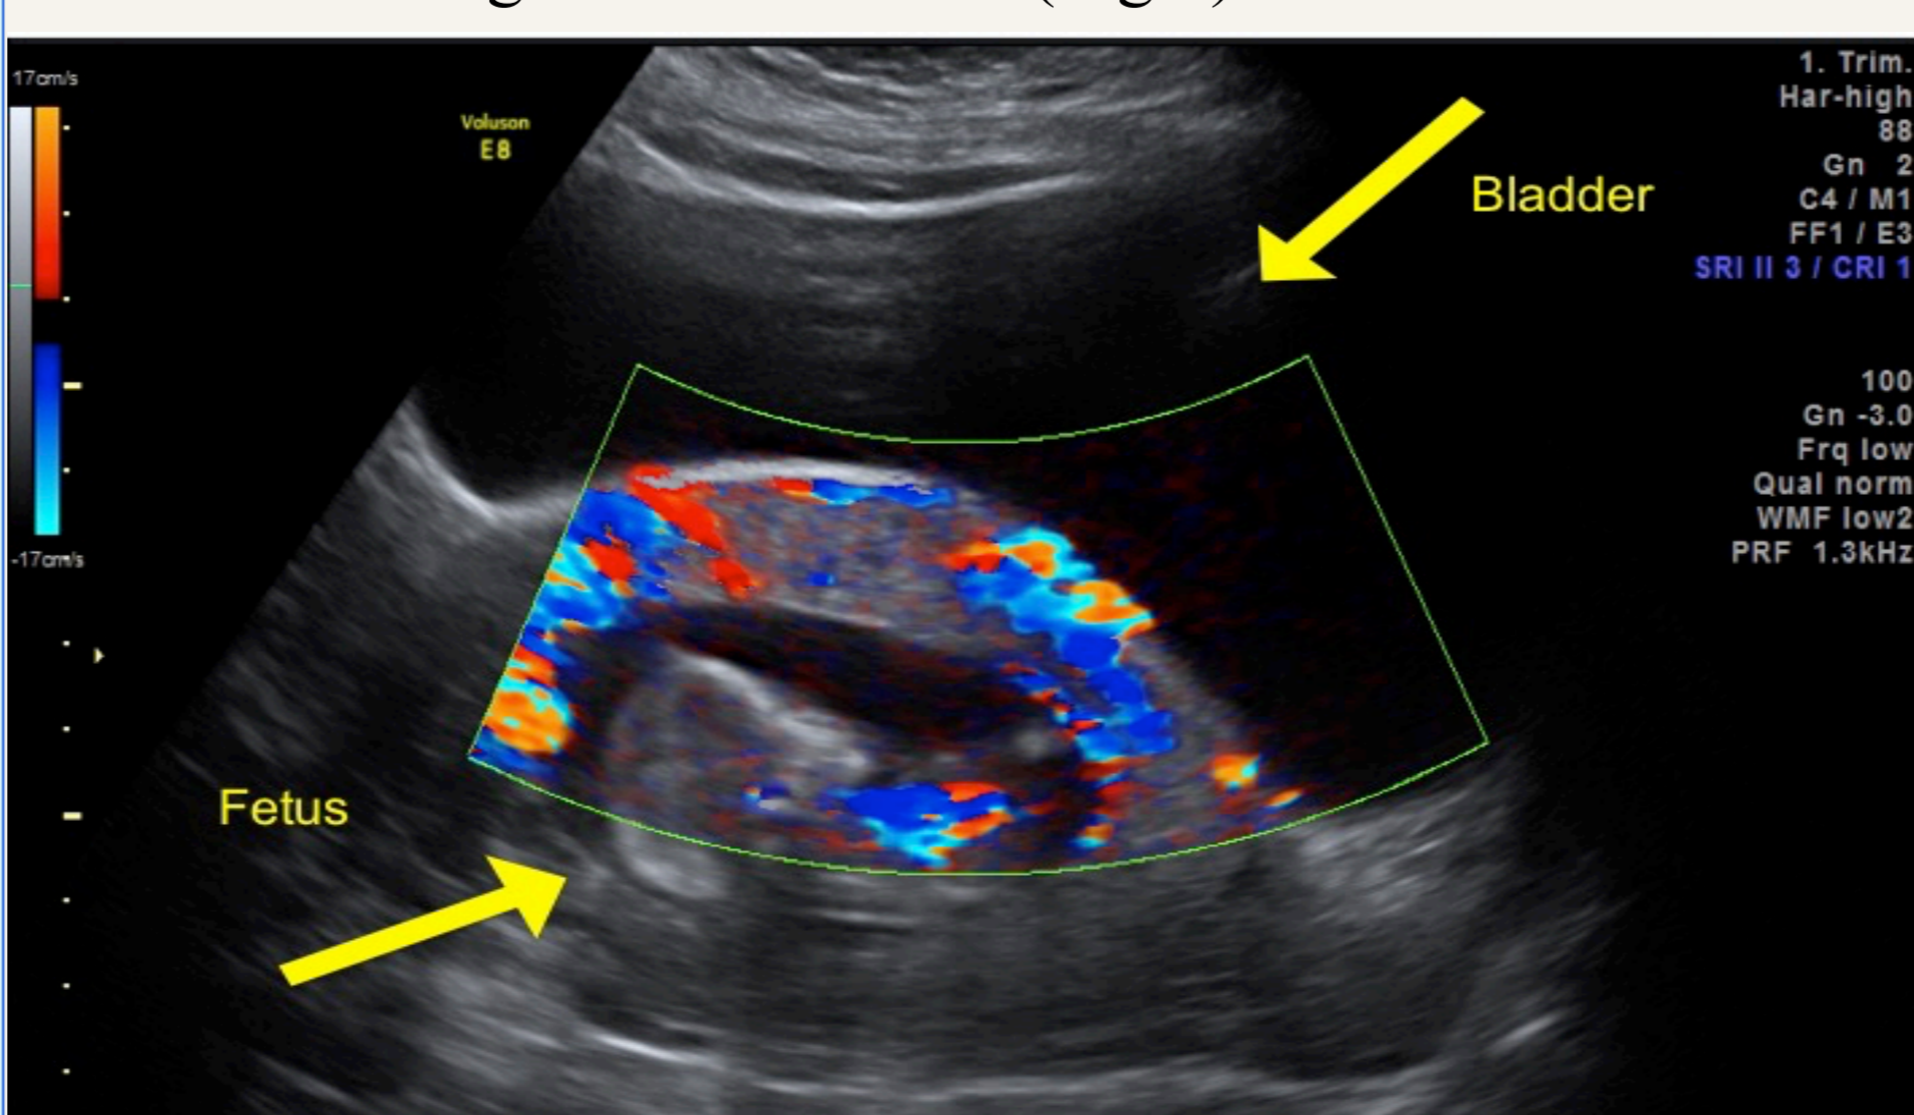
TAUS demonstrating Color Doppler showing marked circumferential peri-trophoblastic vascularity, surrounding the GS.
